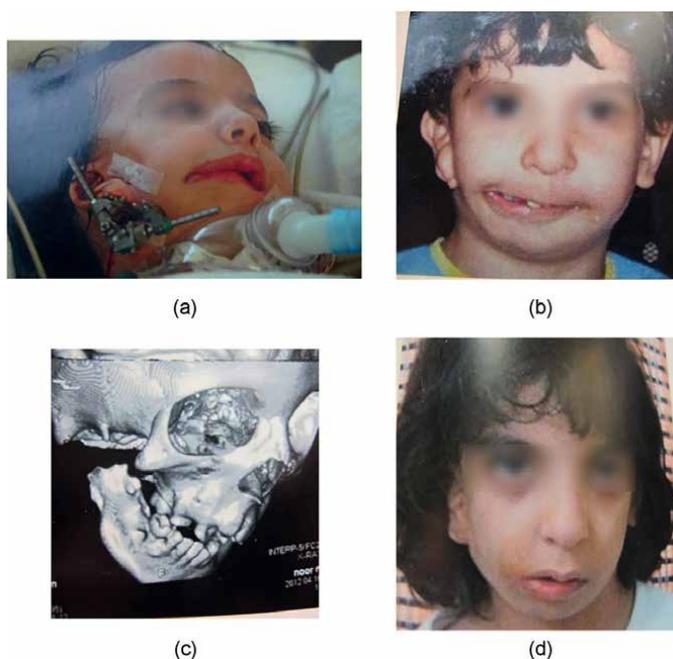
a. Baby born with first arch syndrome treated with distraction techniques with poor results. b. photo showing same child at age 4 years. c. CT scan of female child showing missing ramus and zygomatic arch of temporal bone. d. two-year postoperative photo after series of operations.
